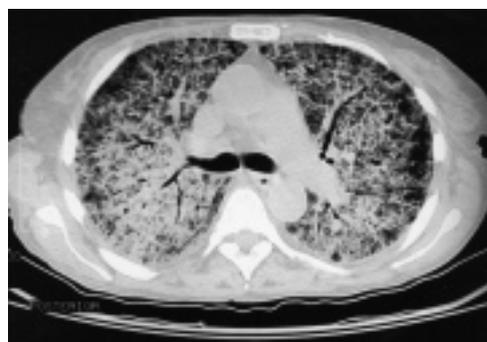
High-resolution computed tomography scan of the thorax at the level of carina.
